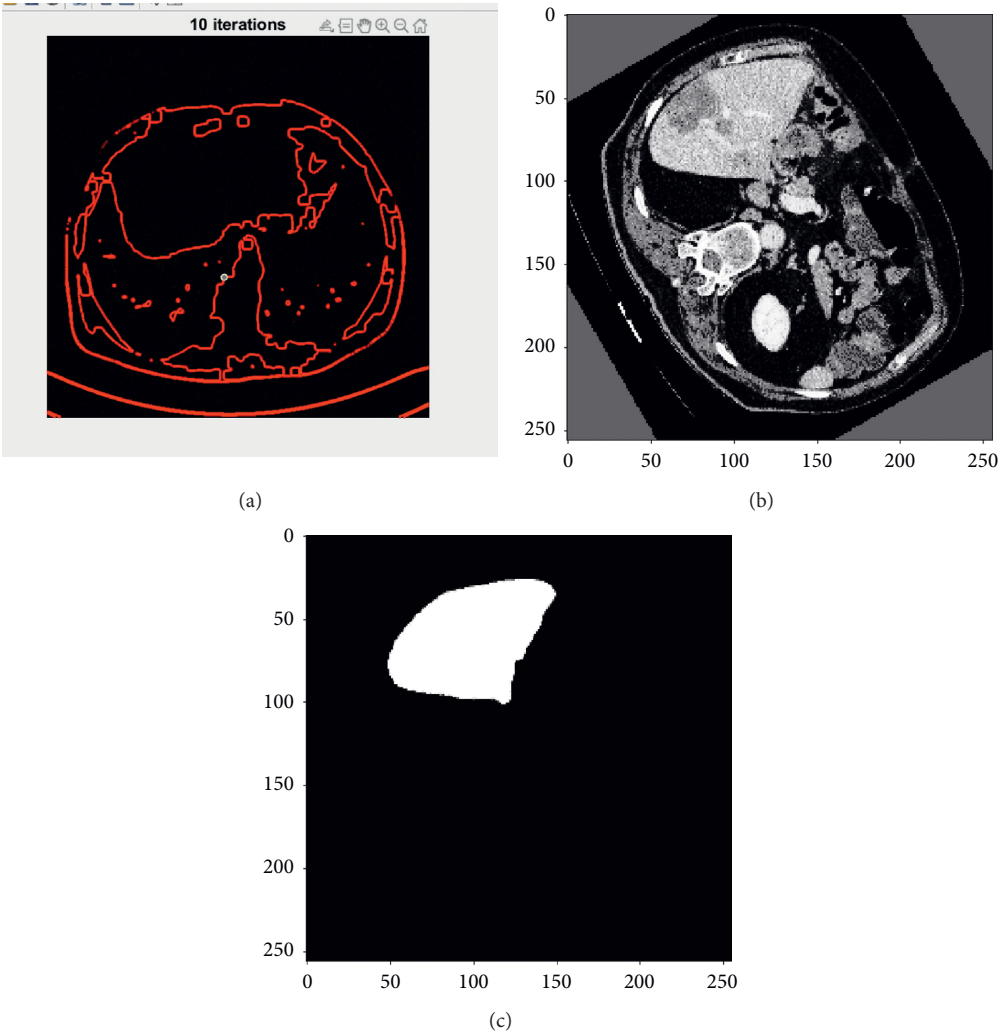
Partial Differential Technique with Input CT image of liver cancer cells.
